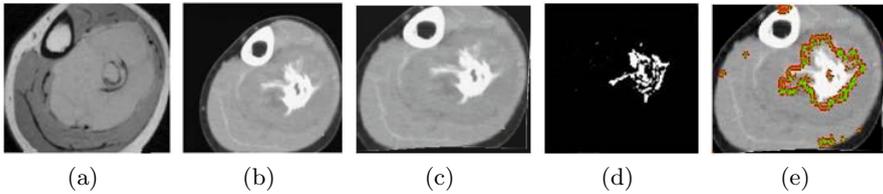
(a) T2 weighted MR image of lower leg , (b) CT image of lower leg, (c) registered image (d) initial region of the tumor region (PFCM classification result), (e) Final segmented tumor region
